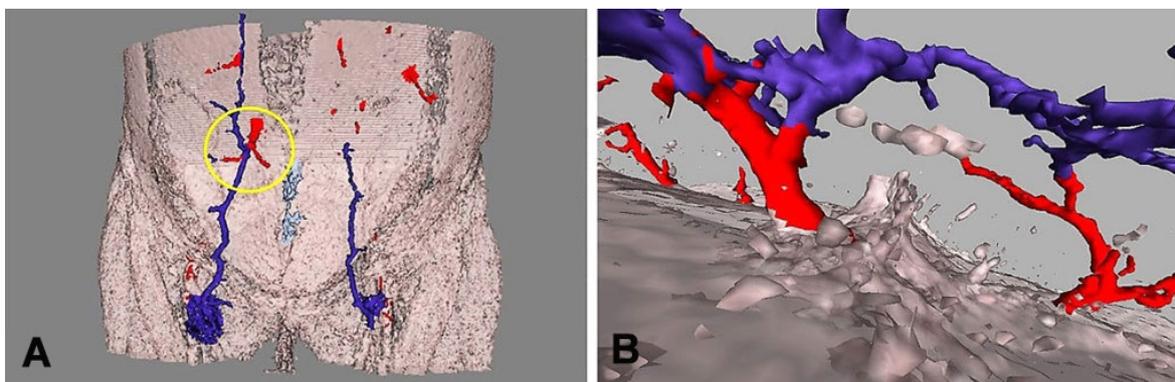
Three-dimensional abdominal wall reconstruction with AYRA software from computed tomography angiography images. (A) Point of assessment (circle) of direct communications between perforators (red) and superficial venous system (blue); (B) direct communications viewed from the abdominal wall
